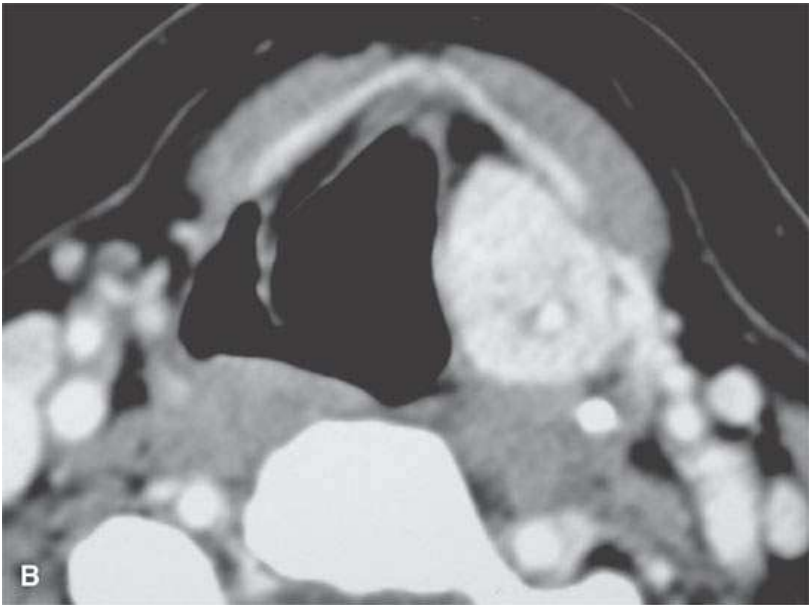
Contrast-enhanced computed tomography of two markedly enhancing lesions, with the degree of enhancement being somewhat unusual for an epithelial tumor. A: Submucosal laryngeal leiomyosarcoma. B: Paraganglioma of the aryepiglottic fold. Note the very large superior laryngeal vascular pedicle (Arrowsarrows).
